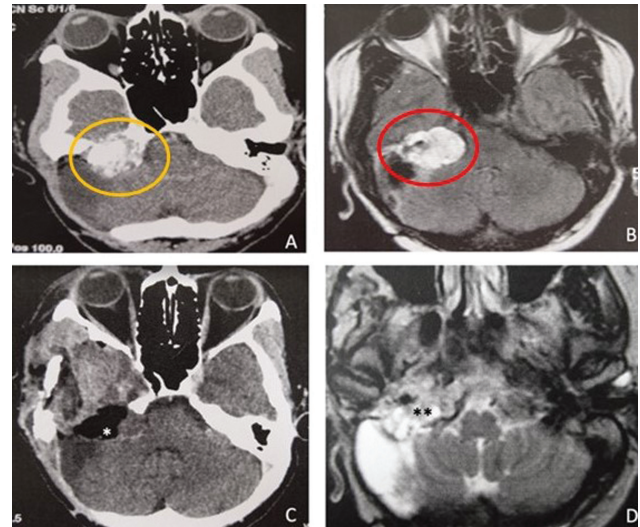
Case 2, a CT scan with contrast two years after surgery (A) and an axial MRI scan of the T1 with gadolinium (B) revealed a tumoral relapse at the petrous apex, which was resected with a new surgery through the middle fossa approach and anterior necrosectomy. Postoperatively showed tumor resection (C). Three years after the last surgery a new relapse occurs on the jugular tubercle, and the tumor is resected again with another surgery. Nine years after the diagnosis the patient succumbed to the disease due to the metastatic dissemination in both lungs. Yellow arrow: tumor seen on CT scans. Red arrow: tumor seen on MRI scans.
